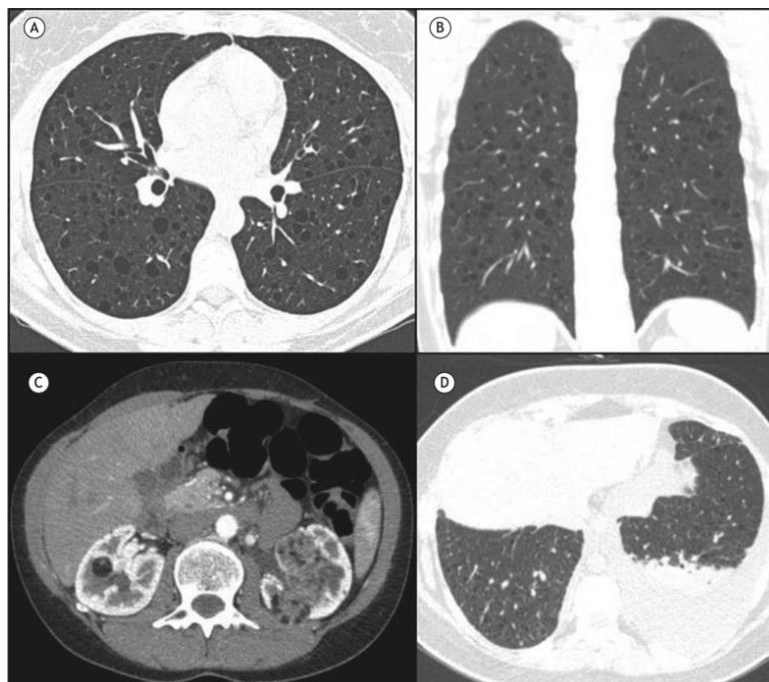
CT scan of a patient with LAM. (A) axial view and (B) coronal view. CT scan of the chest shows diffuse pulmonary cysts with regular walls. (C) axial view. CT scan of the abdomen shows bilateral heterogeneous renal masses consistent with angiomyolipoma. (D) axial view. CT scan of the chest shows diffuse pulmonary cysts and a left chylothorax; Adapted from Baldi et al.¹¹, under the Creative Commons Attribution license.
